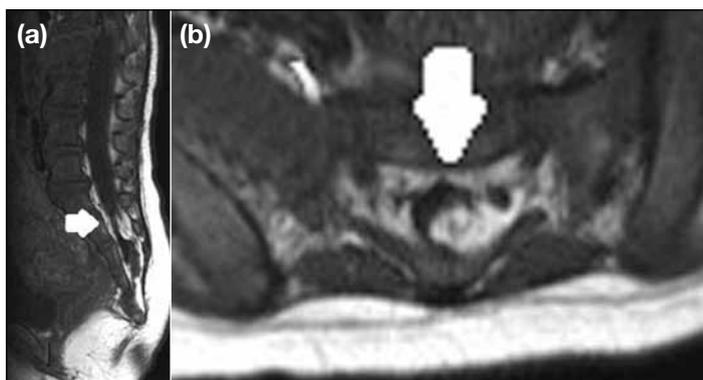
(a) Sagittal and (b) axial T1-weighted magnetic resonance images show a well-defined T1 hyperintense intraspinal mass (arrows) at the S2-4 region, suggestive of a filar lipoma.
